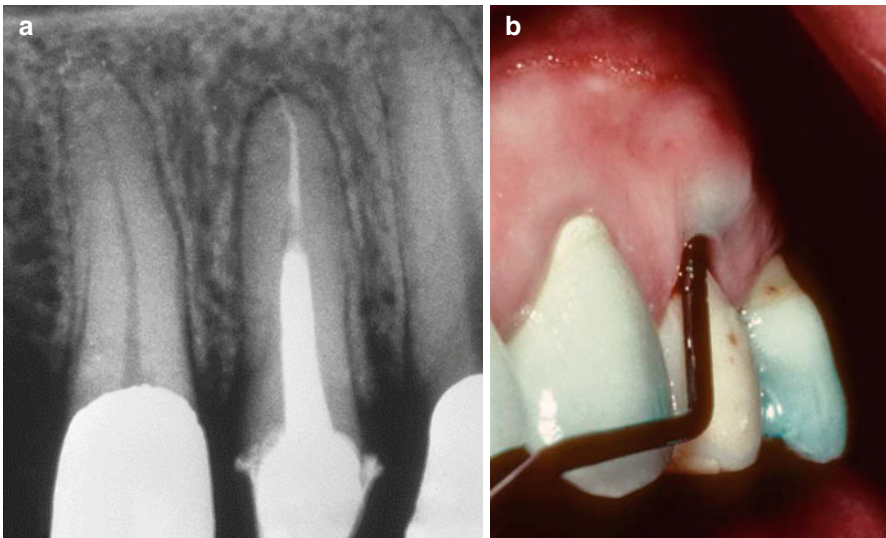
A common finding: (a) there are no significant radiographic changes. (b) A deep probing defect suggests a VRF
